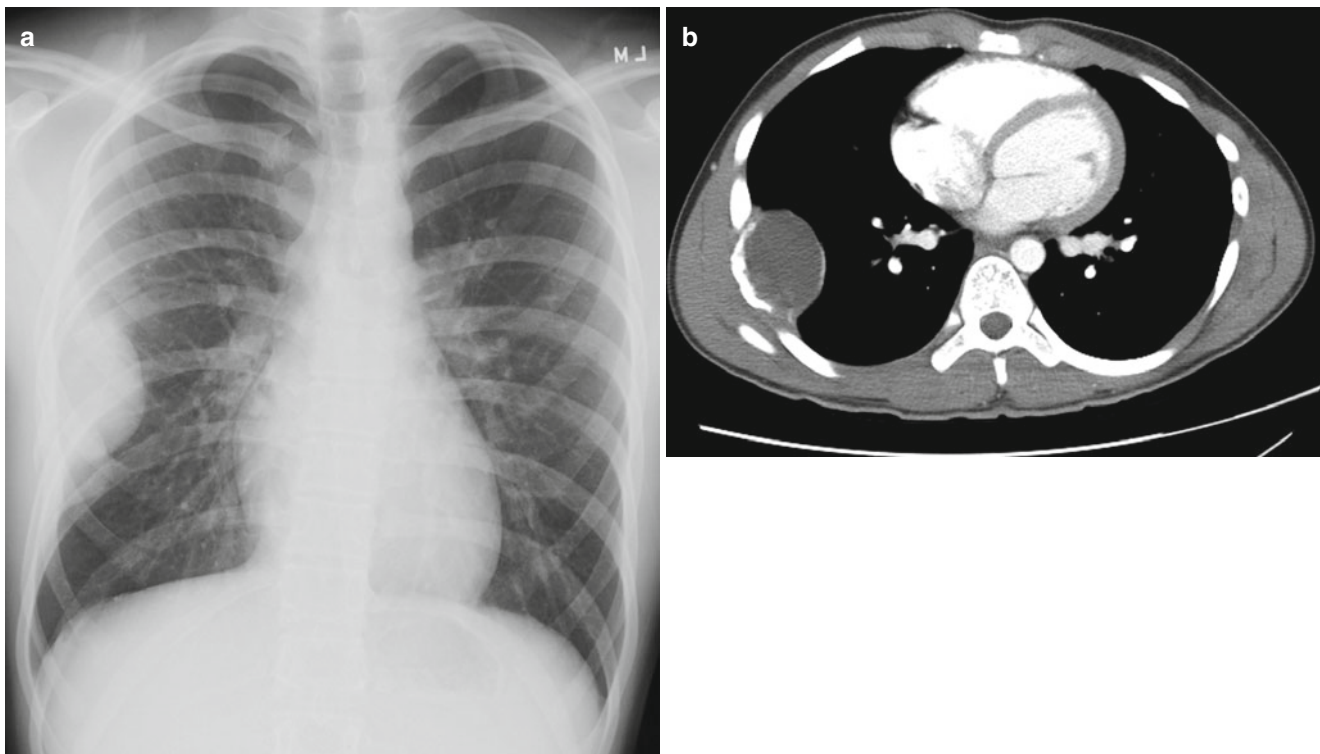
(a) Chest radiograph obtained on a 15-year old boy complaining of chest pain after trauma during a hockey match. It revealed a mass lesion based around the 7th rib. (b) Follow-up CT scan demonstrated a cavitary lesion of the rib. Because of initial concern regarding
